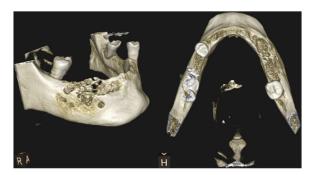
3-Dimensional computed tomographic lateral and occlusal views showing progression of necrotic bone.
